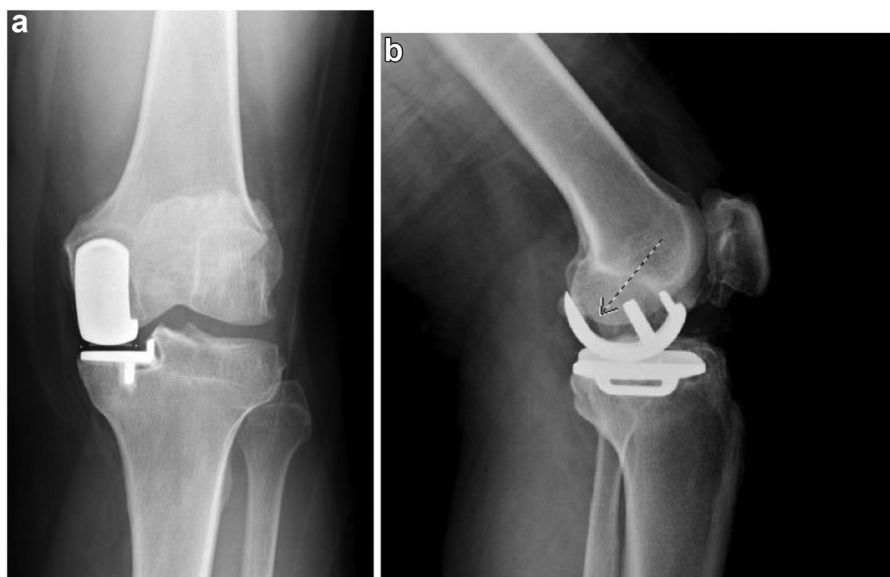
Anteroposterior (a) and lateral (b) weightbearing radiographs demonstrating radiolucency along the medial posterior femoral condyle implant-cement interface (arrow) with progression of patellofemoral and lateral compartment osteoarthritis.
